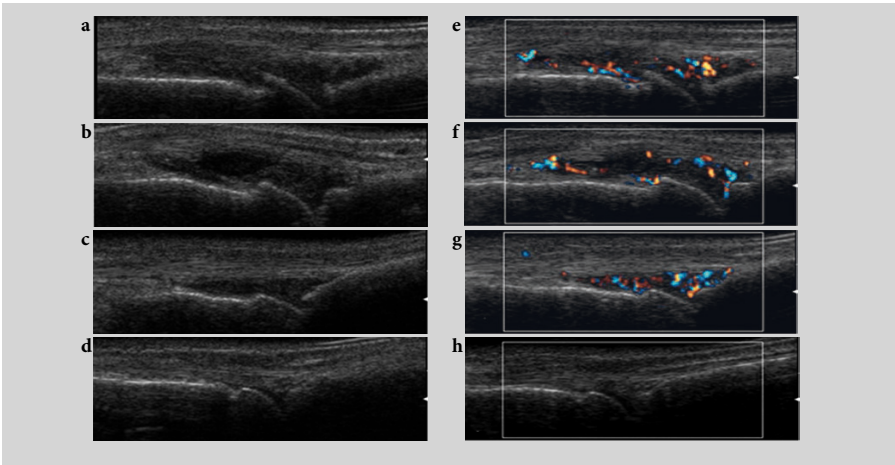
This ultrasound picture shows a longitudinal dorsal scan of four metacarpophalangeal joints with different grade of synovitis. Panels a–d show the grayscale appearance, whereas panels e–h show the same joints when power Doppler is applied.
